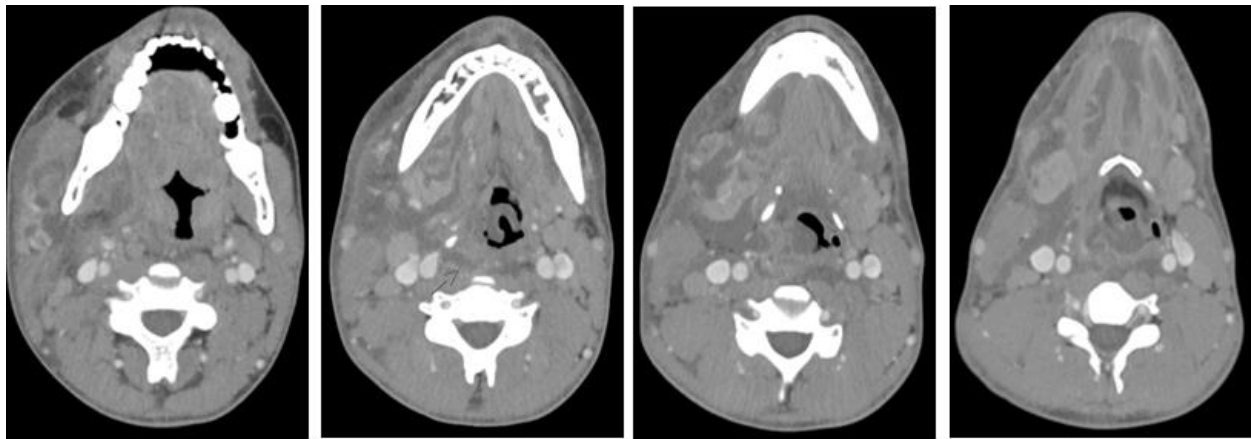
CT scan of the neck with intravenous contrast.
